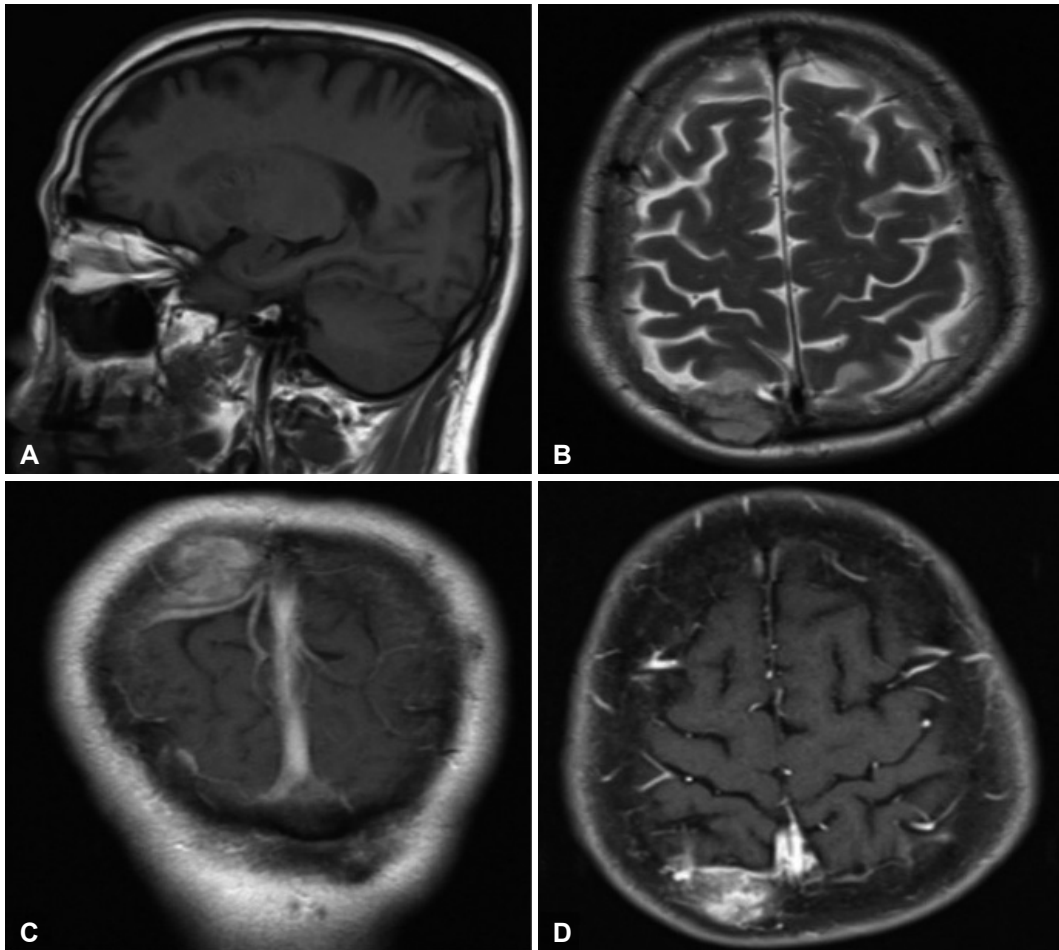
Preoperative magnetic resonance images. T1 saggital weighted (A) MR shows a round shape, scalp bulging, iso-signal intensity. No parenchymal invasion on T2 axial weighted (B) image. Postcontrast T1-weighted MR (C and D) reveal a well-defined, lobulated, enhanced round mass in the right parietal bone (2.06×2.8 cm), with bone destruction and an intracranial extension compressing the brain.
